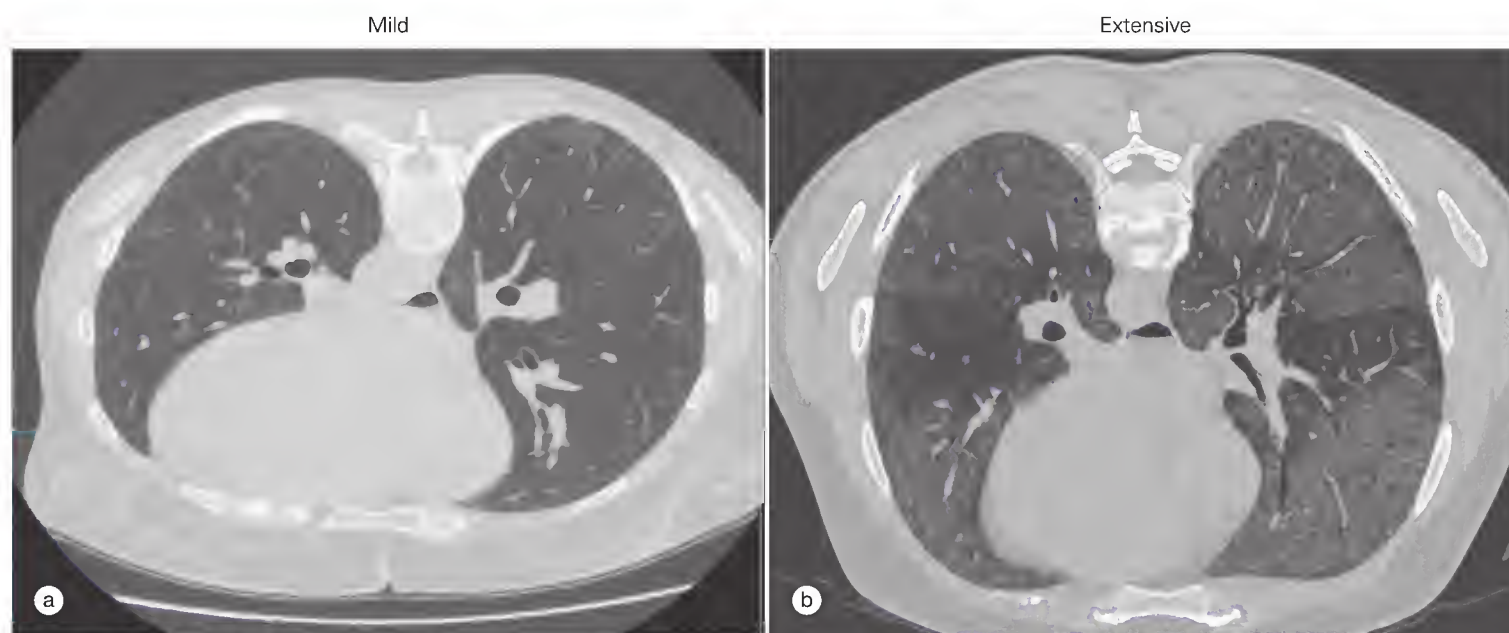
Determining the extent of lung fibrosis in systemic sclerosis (SSc)—a critical role for high-resolution computed tomography (HRCT). (a) Minimal lung fibrosis in early SSc. Initial staging HRCT should be performed with the patient prone so that minor effects of blood distribution or fluid are excluded as explanations for minor basal lung disease. This scan shows trivial disease that would not be associated with chest radiographic findings in the lung fields. (b) Extensive lung fibrosis. This scan shows typical features of extensive lung fibrosis in SSc that will require active treatment because there is a high risk of future decline. In these scans more than 75% of the lung field is involved.
